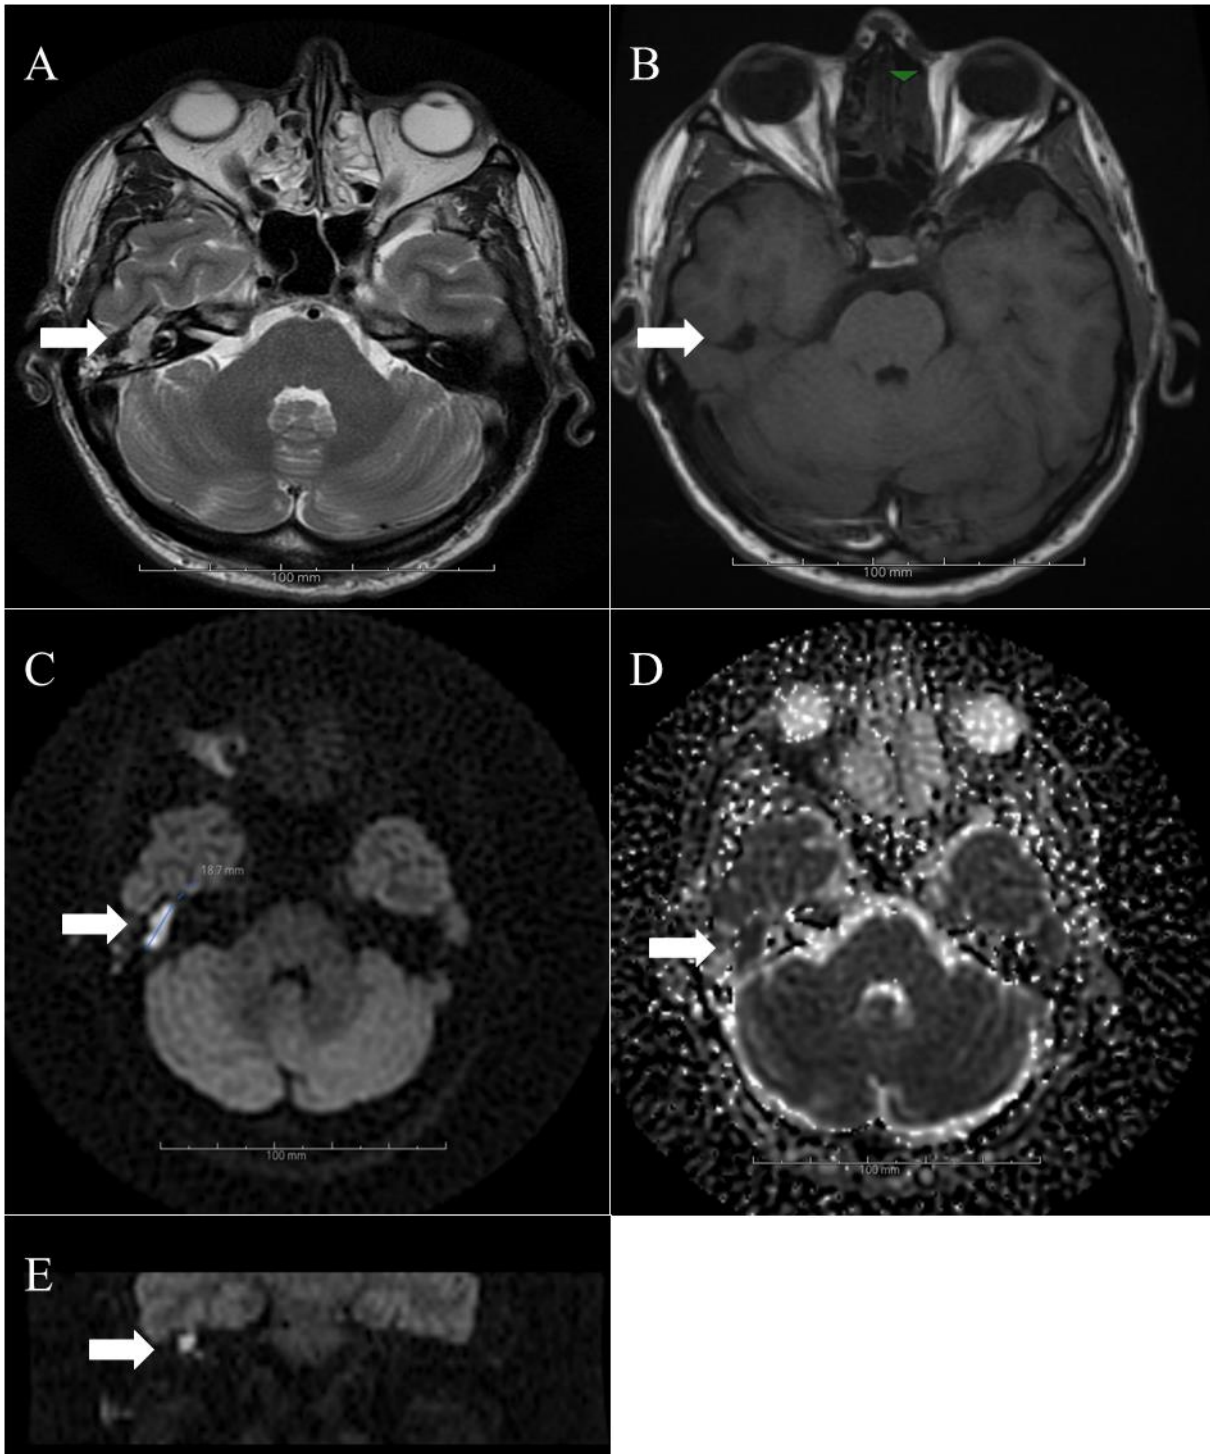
MRI confirmation of recurrent cholesteatoma in a case with inconclusive otologic exam results. A 34-year-old female, under a five-year follow-up, presented with mildly progressive decreased hearing. The otologic examination was obscured by cartilage reconstruction and an opaque tympanic membrane. The white arrows in all images point to the cholesteatoma. a) MR imaging shows a slightly hyperintense signal on T2WI and (b) a Hypointense signal on T1WI without clear enhancement; c) ROPELLER DWI shows hyperintensity in this same area, consistent with recurrent cholesteatoma. Surgical findings confirmed the presence of cholesteatoma in this region; d) The ADC map presents with a hypointense signal; e) Coronal image, reformatted from the axial PROPELLER DWI exhibits hyperintensity.
